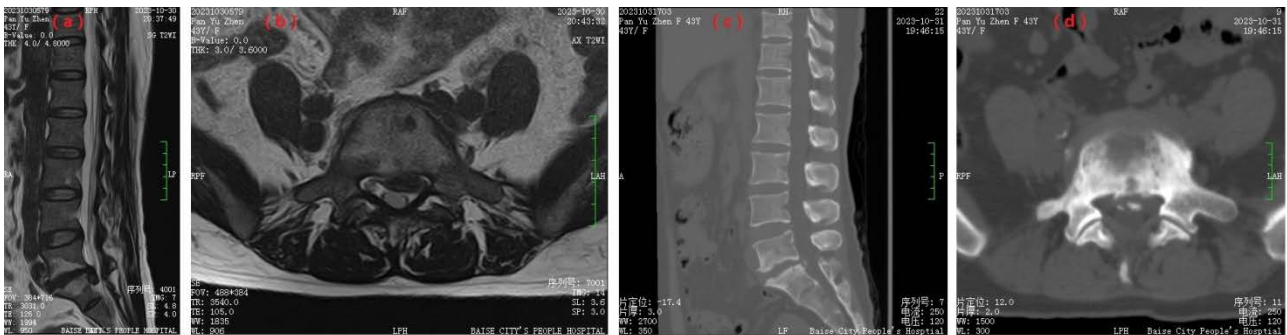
Figure a: MR lumbar spine sagittal view ; Figure b: MR lumbar spine axial view ; Figure c: CT lumbar spine sagittal view ; Figure d: Lumbar spine axial view ; Figures a and b clearly indicate the protruded segment and the situation of spinal canal stenosis before the surgery ; Figures c and d also clearly indicate the protruded segment and the situation of spinal canal stenosis before the surgery.
